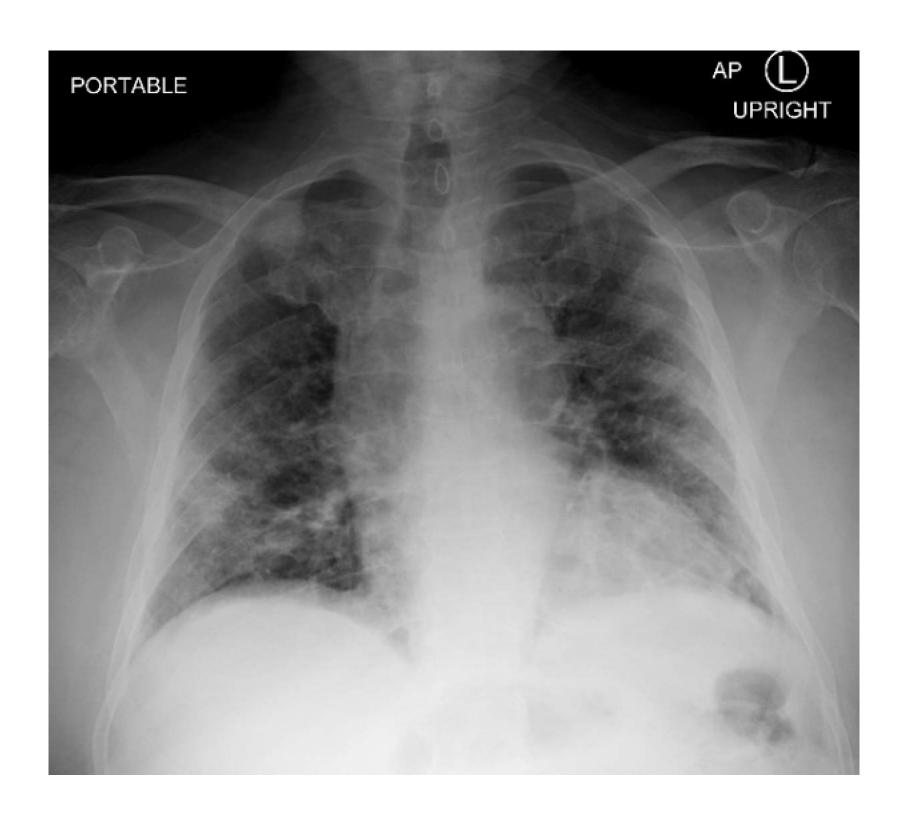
AP Chest X-Ray demonstrating ill-defined densities in the lower lung suggestive multifocal pneumonia characteristic of COVID-19
